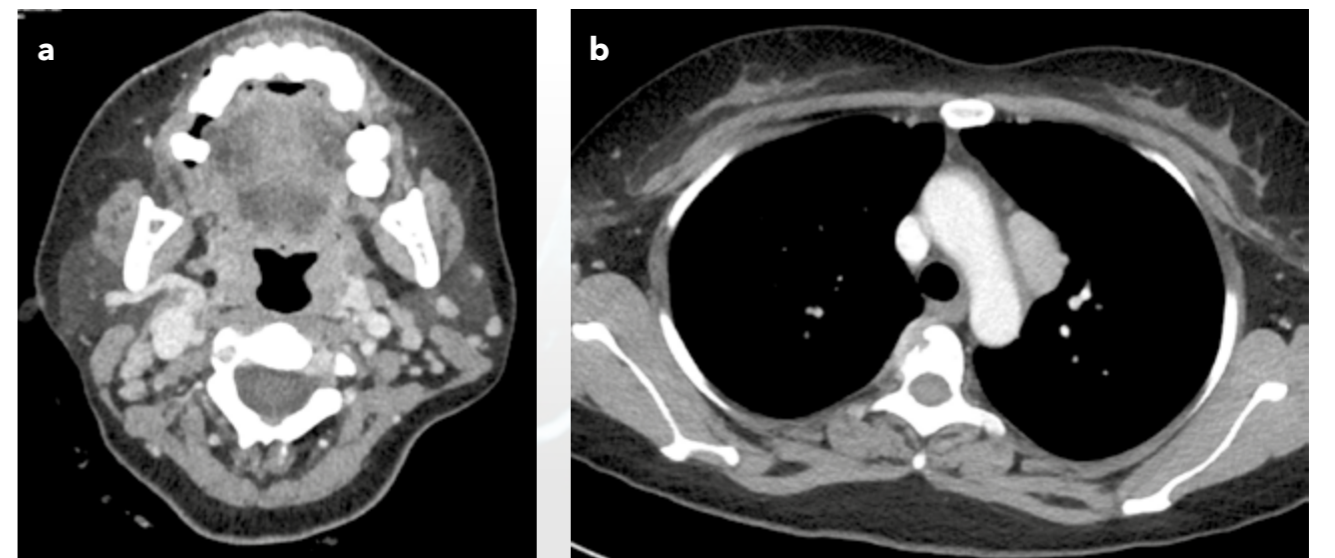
Axial contrast-enhanced CT of (a) Neck and (b) Thorax.
